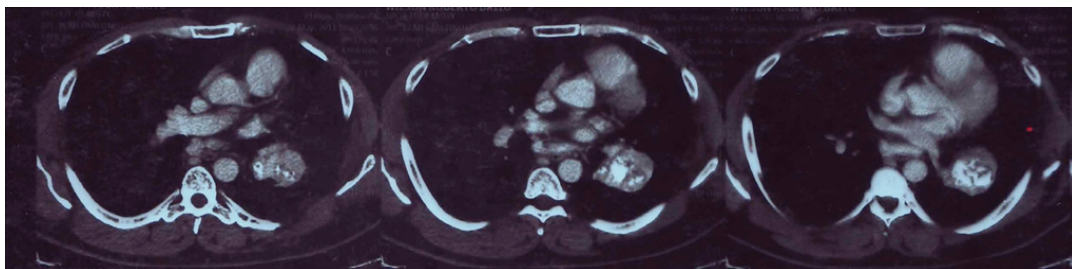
From left to right, chest CT scans of the lesion at 1, 2, and 3 years of follow-up. Note an increase in the size of the calcified area within the treated lesion.
